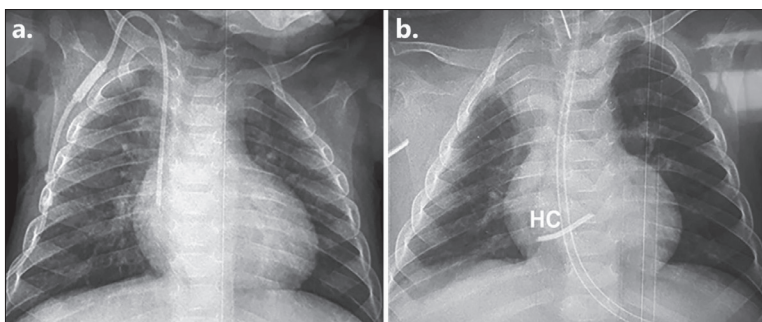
The preoperative chest X-ray (a); the postoperative chest X-ray (b); HC – the part of the Hickman catheter
